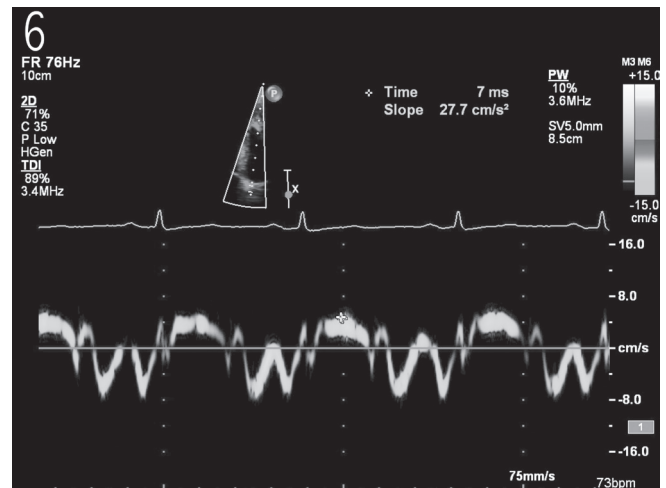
Tissue Doppler demonstrating a reduced E' in keeping with diastolic dysfunction.
